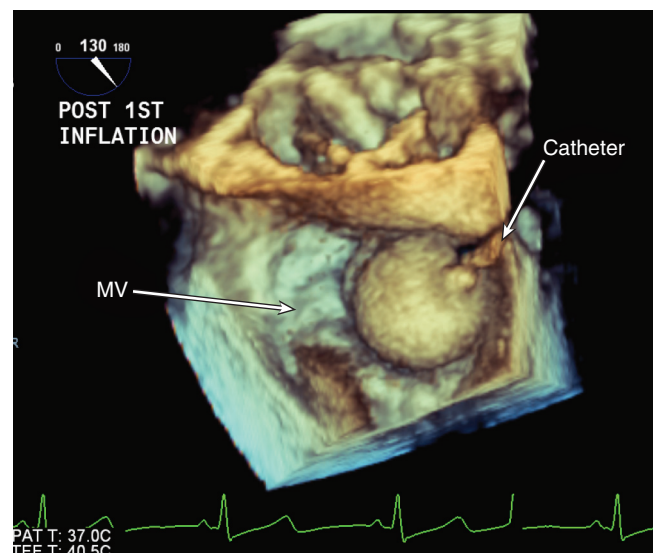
■ Three-dimensional transesophageal echocardiography during a mitral valvuloplasty procedure imaged from the atrial side of the valve with a catheter crossing the valve and the valvuloplasty balloon inflated. MV, Mitral valve.
